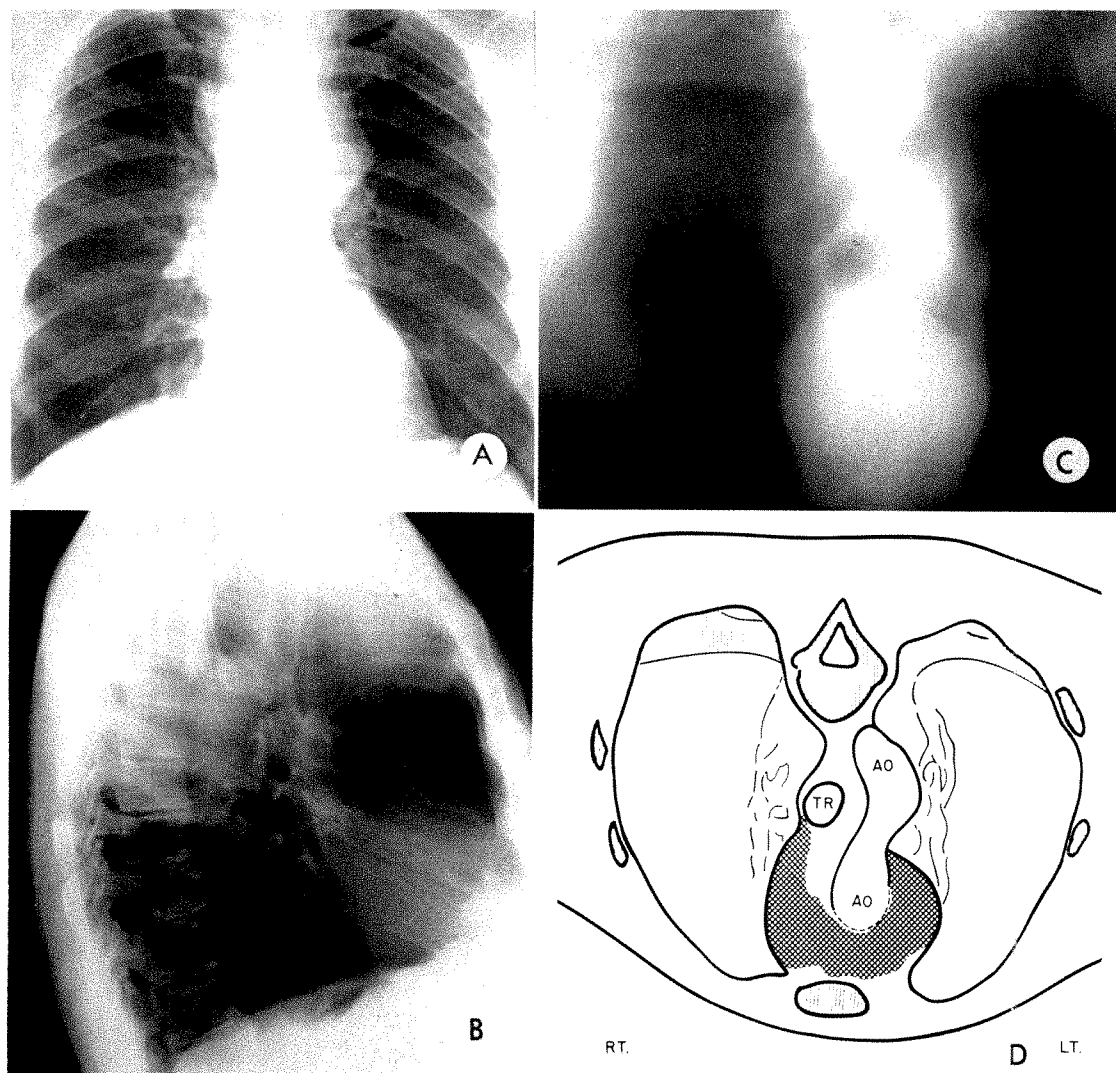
Case VII. This white male, sixty-nine years of age, was admitted to the hospital for evaluation and treatment of an anterior mediastinal mass. The anterior and upper borders of the tumor appear well defined and symmetric on the conventional roentgenograms (*A* and *B*). Yet the extent of the mass in its posterior direction and its relation to the great vessels cannot be demonstrated with these procedures.
